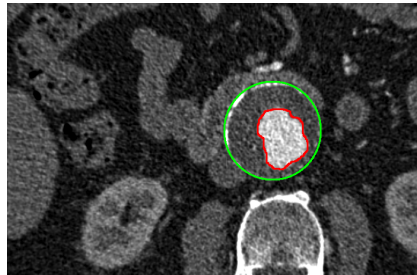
An example of an contrast-enhanced CT scan of an abdominal aortic aneurysm with segmented thrombus (outer green contour) and lumen (inner red contour)
